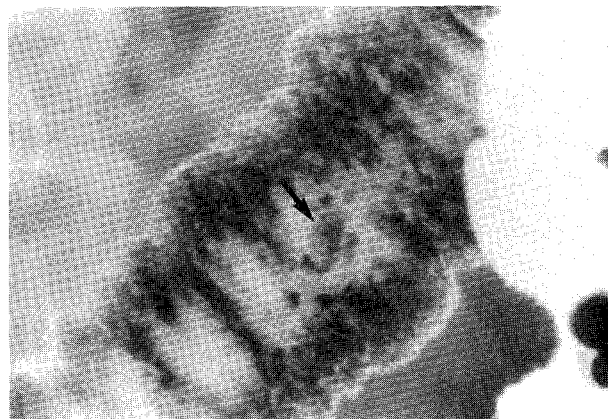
Inflammatory polyp in a patient with active ulcerative colitis (arrow). Filling defects with radiographic evidence of inflammatory changes are seen.
